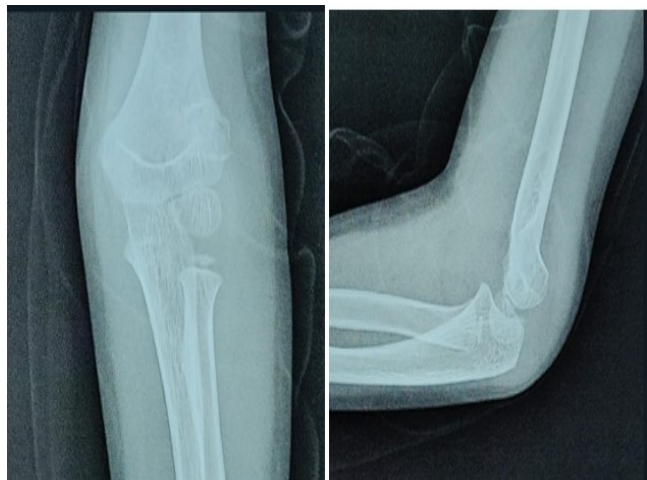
Pre-operative radiograph shows Type IIA left supracondylar humerus fracture in a 6-year-old child.
